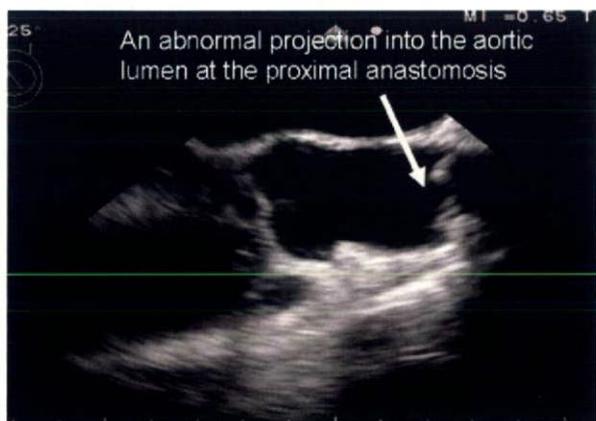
Transesophageal echocardiography image demonstrates an abnormal projection into the aortic lumen at the proximal anastomosis (arrow).
